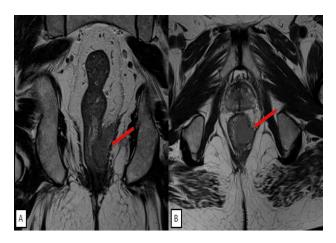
(A and B): Left-sided rectal mass (red arrow) invading the mesorectum on MRI; coronal plane; and transverse plane.
